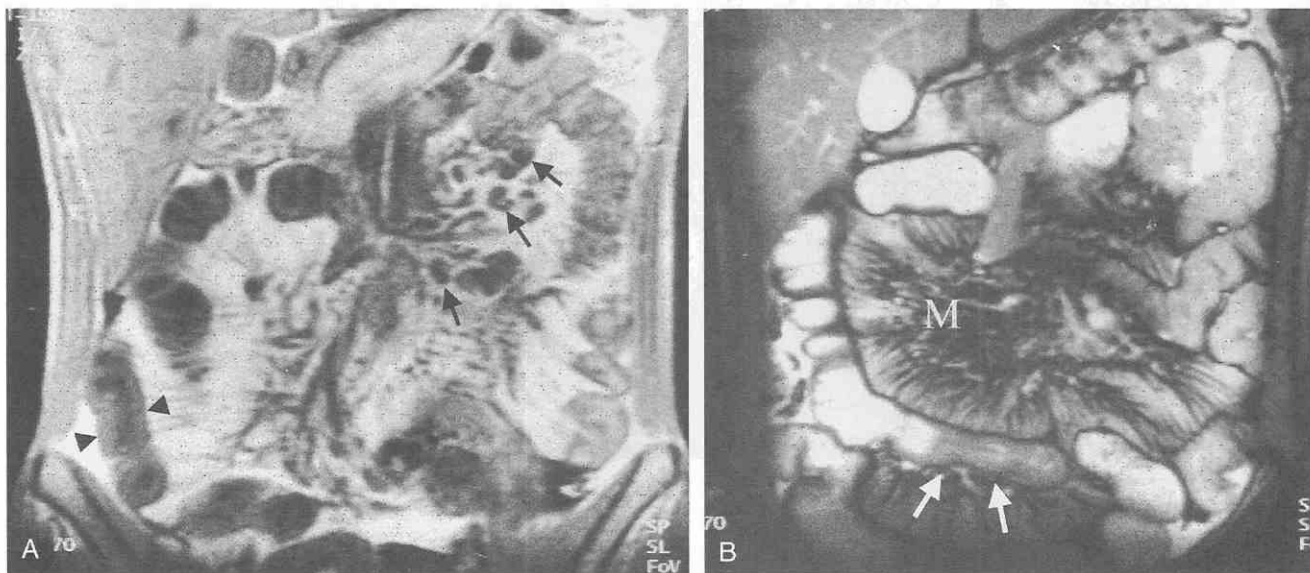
Crohn's disease. A, T1-weighted MR image shows mesenteric lymphadenopathy (arrows), especially along the jejunal branches of the mesenteric artery. Note the bowel wall thickening (arrowheads) of the ascending colon. B, Coronal true fast imaging with steady-state precession (FISP) MR image shows fibrofatty proliferation (M) with hypervascularity ("comb sign") of mesenteric vasculatures. Also note the focal bowel wall thickening (arrows) and pseudosacculation along the antimesenteric border of the adjacent bowel loop.
